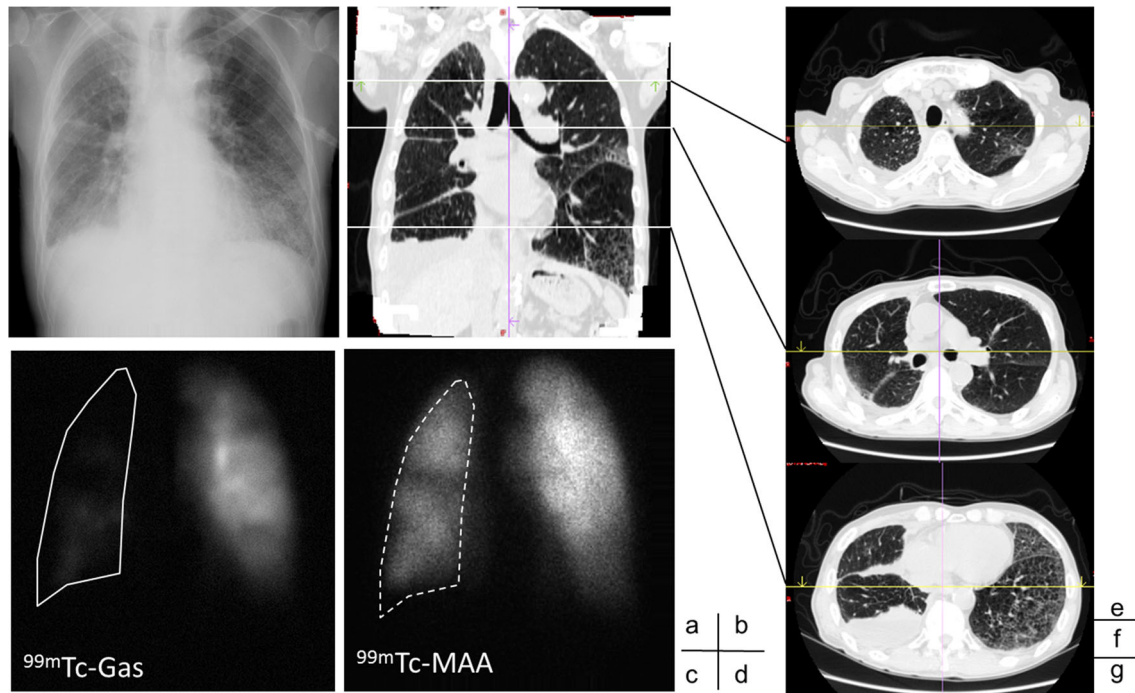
Image findings of the patient with pleural adhesions (74-year-old man). (a) Chest radiograph, (b) CT image (coronal view), (c)-(d) ventilation and perfusion scintigrams. The right lung shows
